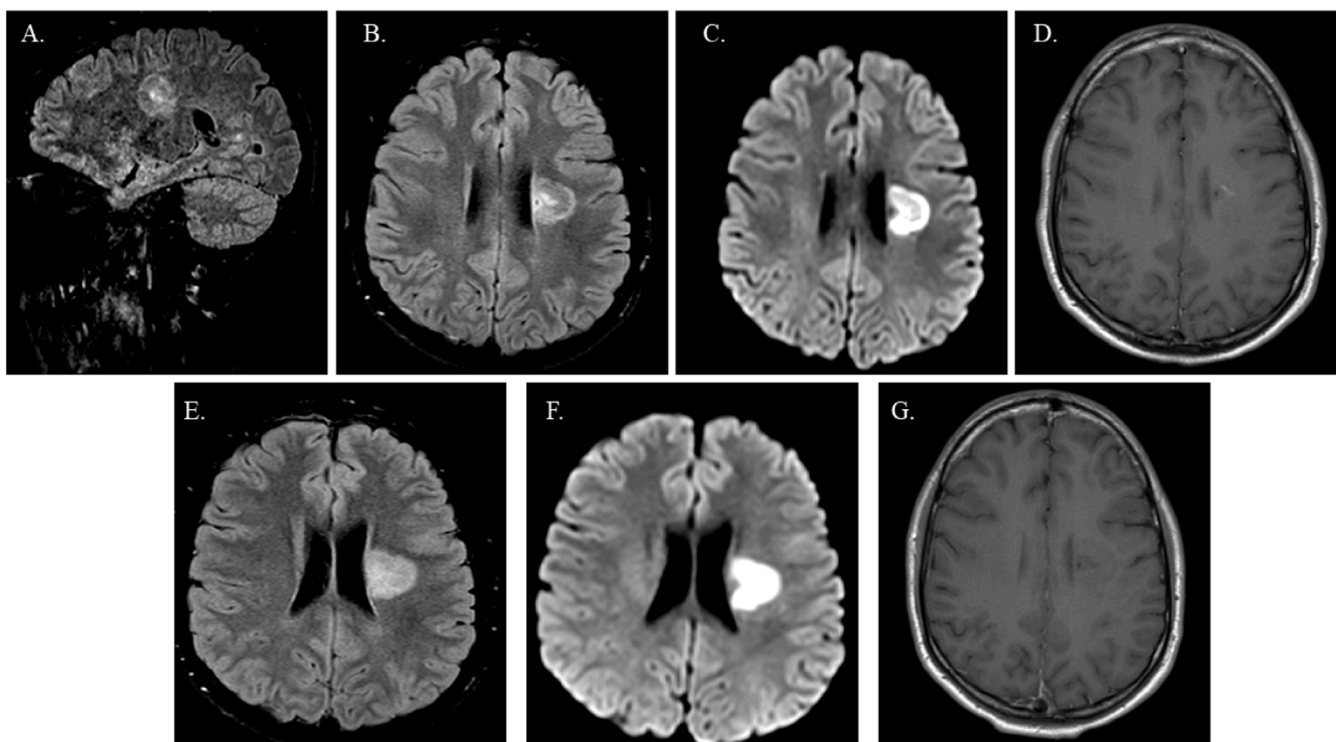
Initial and follow-up magnetic resonance images of patient 1.
